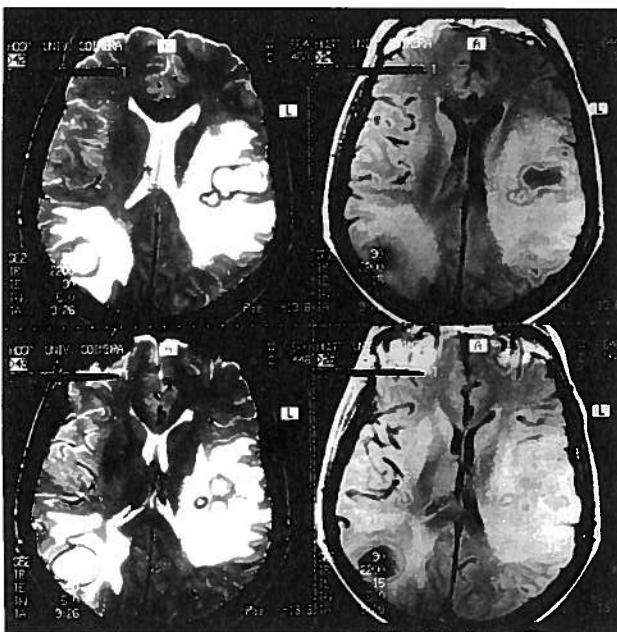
and 2B - MRI of the cranium performed on 26/5/92 reveals multiple rounded lesions with abundant enveloping edema.
